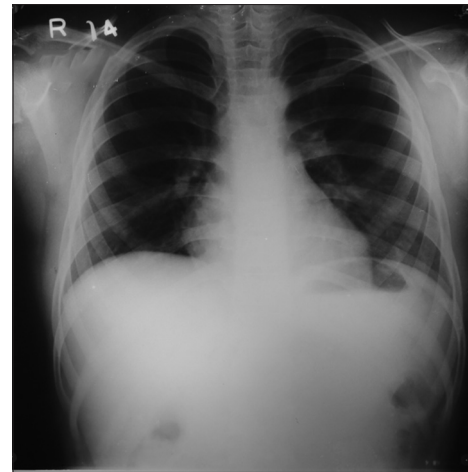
Posteroanterior chest radiograph showing clear field indicating absence of foreign body material
